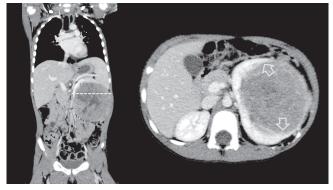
CT scan showing left-side Wilms tumor in a 4-yearold boy. Yellow arrows depict a bird beak signs which discriminate an intrarenal mass from renal parenchymal compression from an extrarenal lesion.
